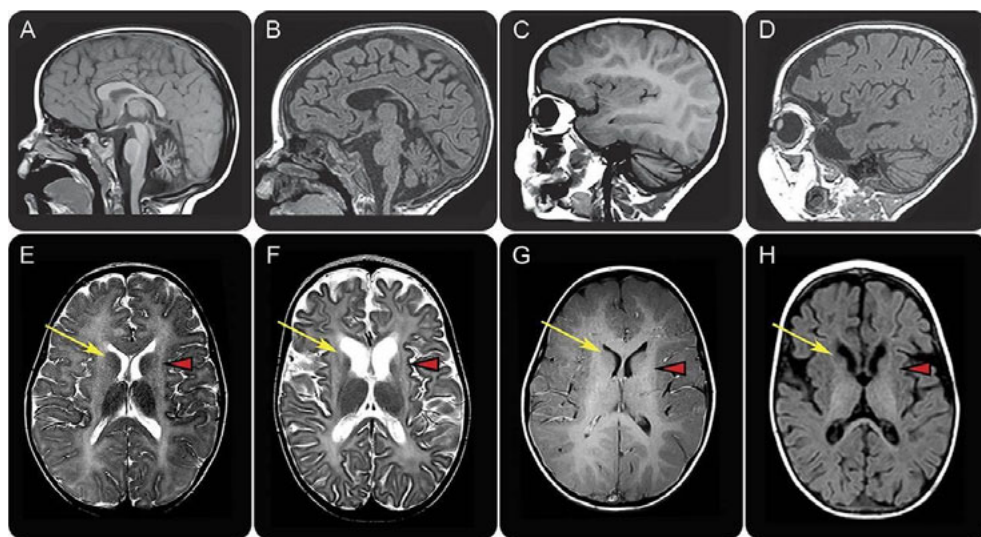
MRI findings in *TUBB4A* (left) and *UFM1* (right) mutated patient with hypomyelination with atrophy of the basal ganglia and cerebellum. Sagittal T1-weighted (A-D) and axial T2-weighted (E, F) and T1-weighted (G, H) images in a patient with the common dominant c.745G>A *TUBB4A* mutation at age 3 years (A, C, E, G) and a patient with the homozygous recessive *UFM1* mutation at age 13 months (B, D, F, H). The patient with the common *TUBB4A* mutation shows a mildly hyperintense white matter signal on T1-weighted (C, G) and T2-weighted (E) images, indicating a moderate lack of myelin. In the *UFM1*-mutated patient, the white matter T1 signal is hypointense, indicating a profound lack of myelin (D, H). This patient also shows mild cerebral atrophy (F, H). Both patients have a mild cerebellar atrophy (A-D), most notable at the vermis (A, B). In both patients, there is no putamen visible and there is no visible lesion in this region (arrowheads in E-H). In the *TUBB4A*-mutated patient, the caudate nucleus has a normal signal (arrow in E). In the *UFM1*-mutated patient, the caudate nucleus is atrophic and the lateral part of the head has an abnormal hyperintense T2 signal (arrow in F) and hypointense T1 signal (arrow in H).
